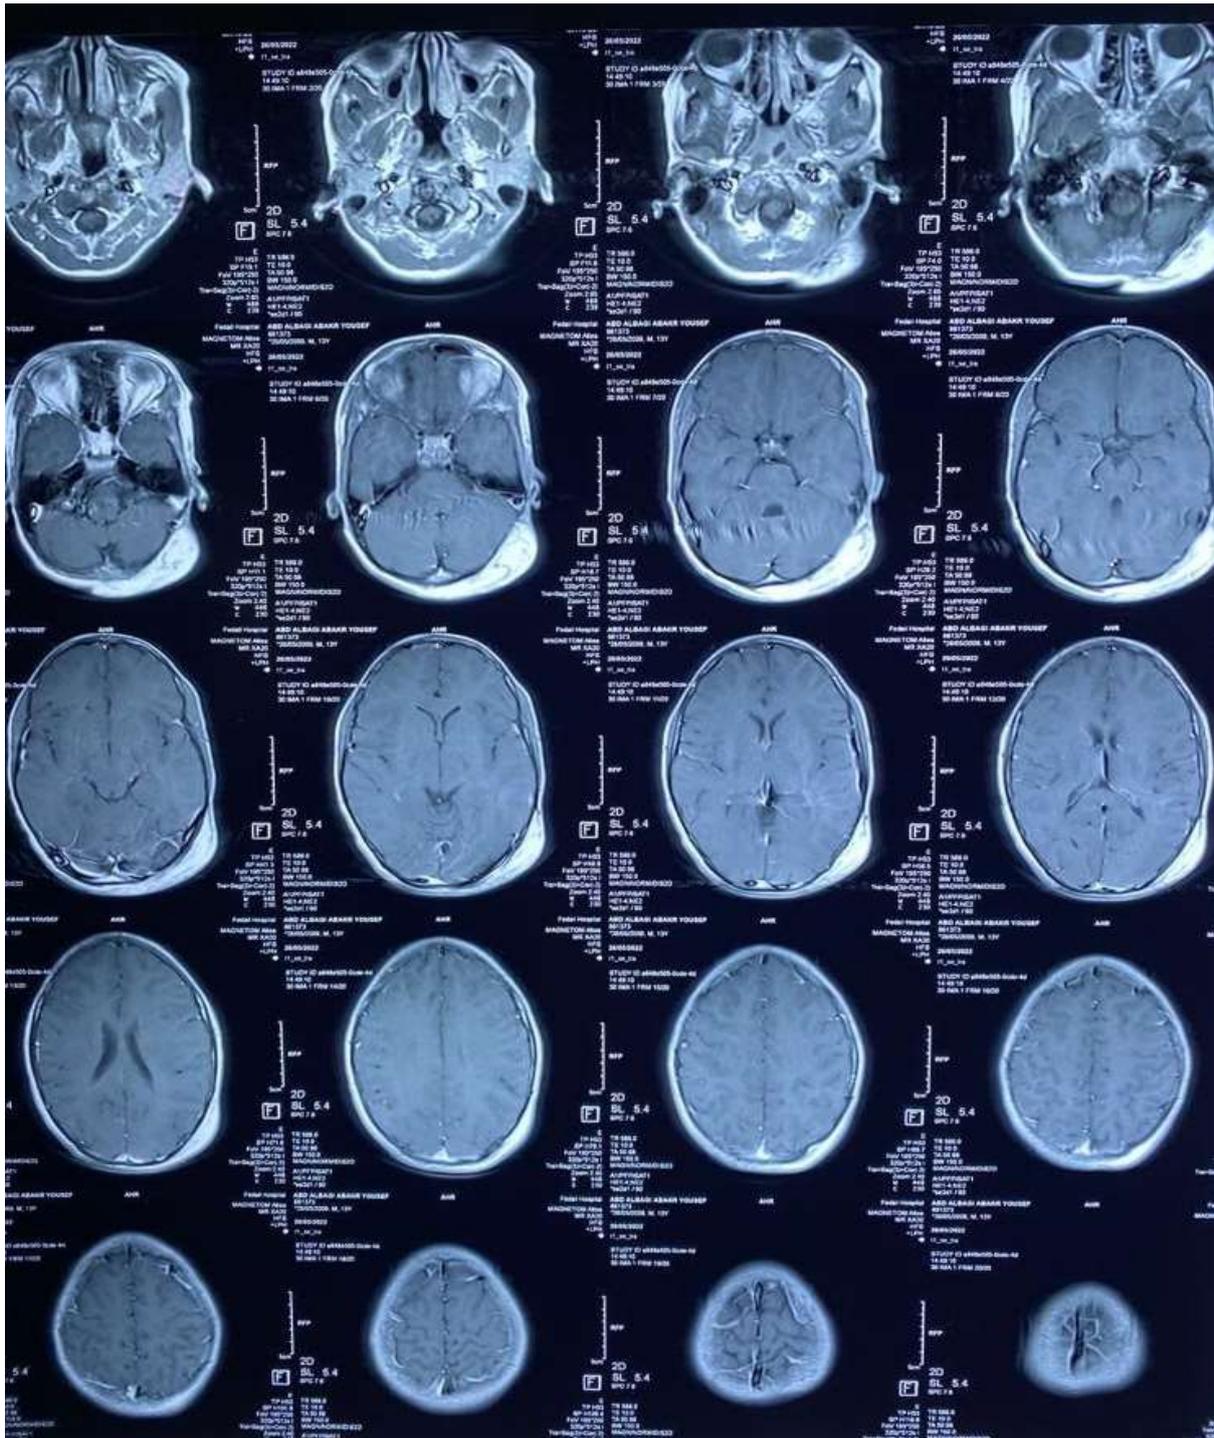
MRI brain with contrast axial cut shows the lesion enhancing intensely and purely extra cranially.
